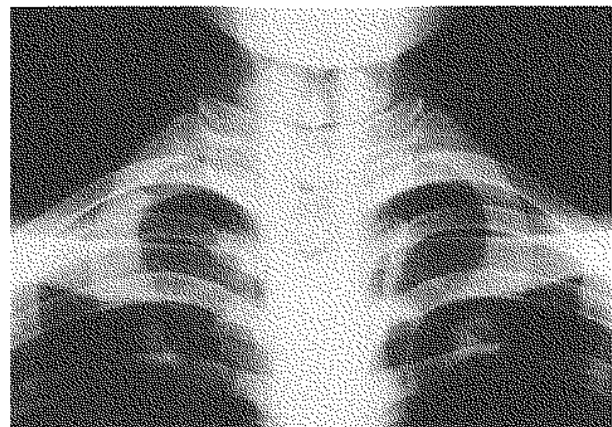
An AP radiograph of the upper chest taken when the patient visited the private clinic, complaining of pain in the right anterior chest. There is a transverse fracture line at the posterior one-third of the right first rib. No fracture is seen in the left first rib.
